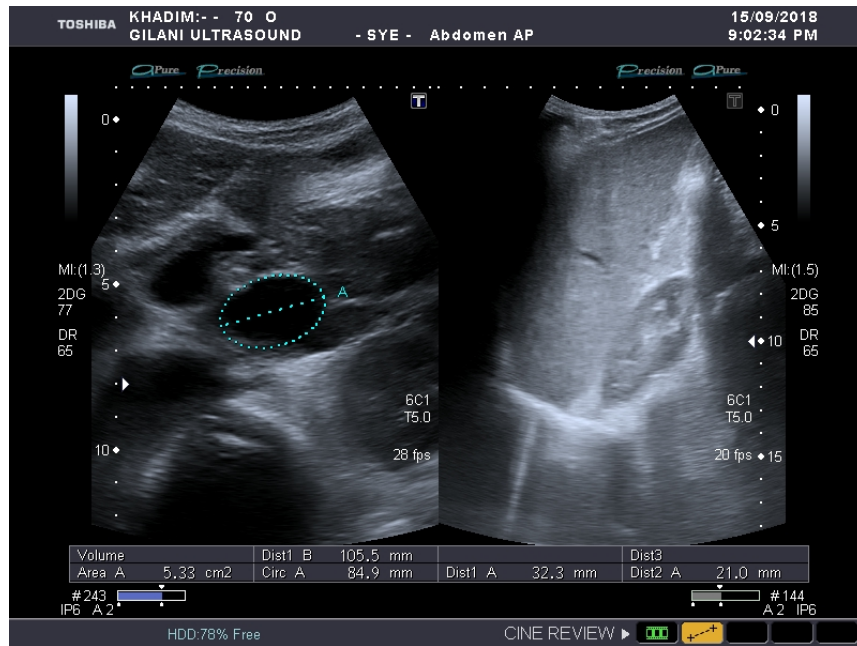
Ultrasound image showing normal portal vein diameter with fatty fibrotic liver parenchyma.
